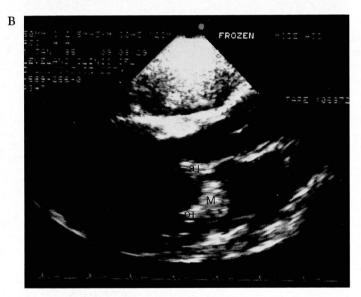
M-mode echocardiogram obtained at the level of the mitral valve. A large echodense mass (arrows) is seen attached to the posterior leaflet of the mitral valve. FIGURE 1B. Two-dimensional echocardiogram (long-axis parasternal view). A large echodense mass is attached to the posterior leaflet of the mitral valve. m = mass, lw = left ventricle, mw = mitral valve, al = anterior leaflet, and pl = posterior leaflet.
